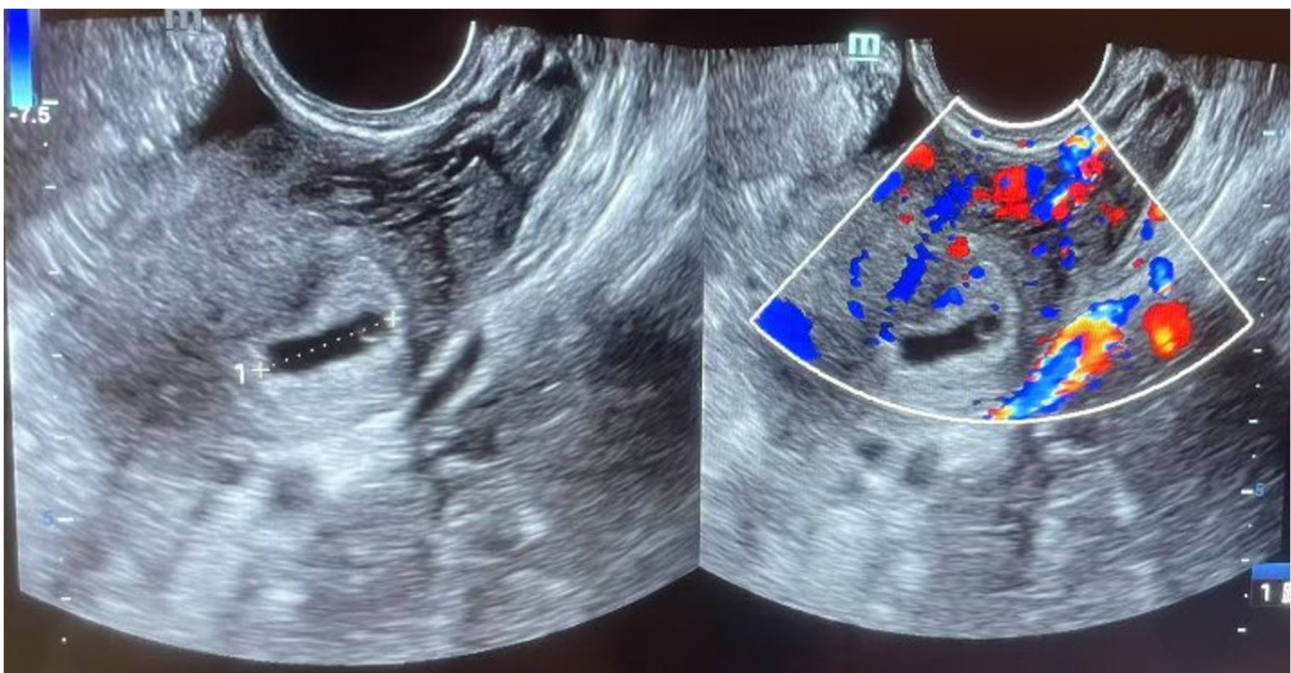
A representative ultrasound of early pregnancy.
